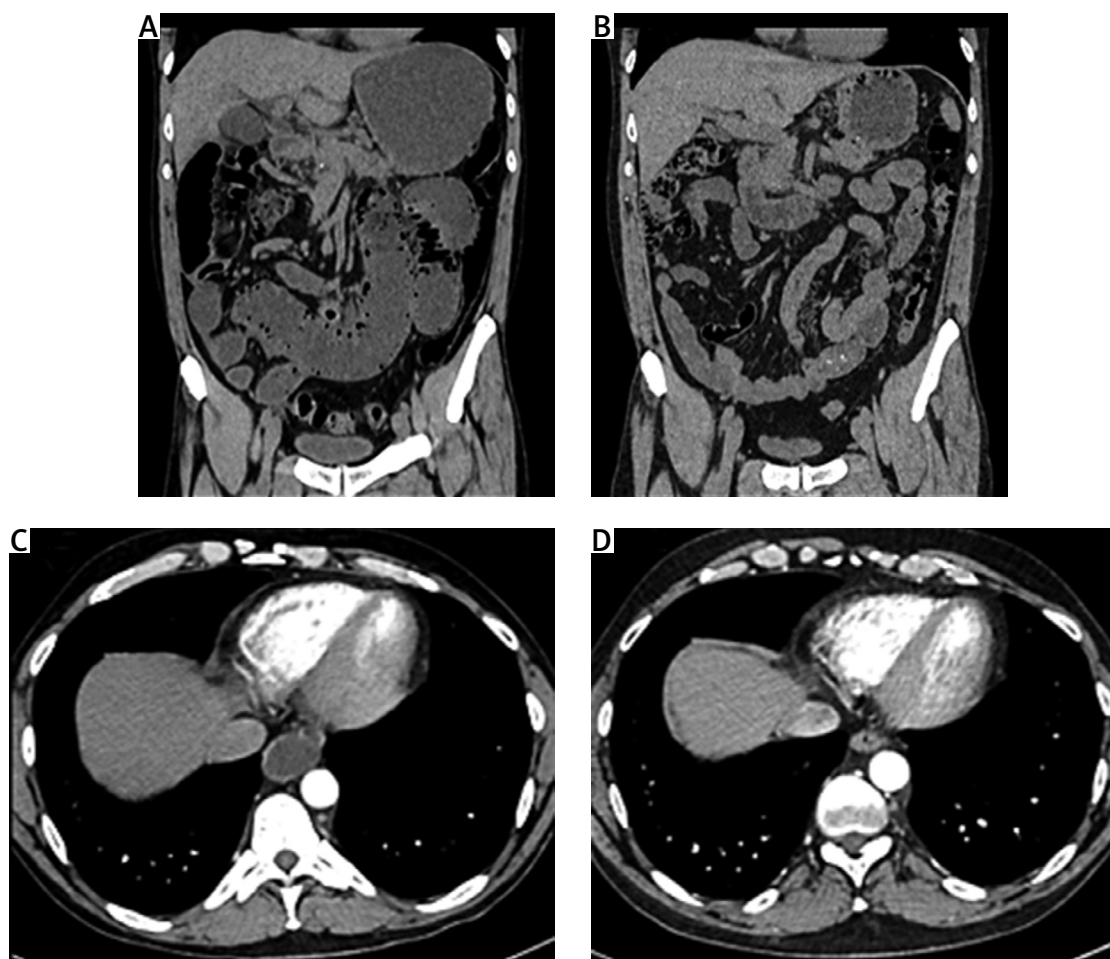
A) Frontal abdominal CT scan during pseudo-obstruction episode in July 2023 showing dilated intestines, stomach, and pneumatosis intestinalis. B) Frontal abdominal CT scan after 12 months (July 2024) of treatment showing improvement in intestinal and stomach dilatation. C) Transverse chest CT scan in July 2023 showing oesophageal dilatation and D) transverse chest CT scan in July 2024 showing its regression.
